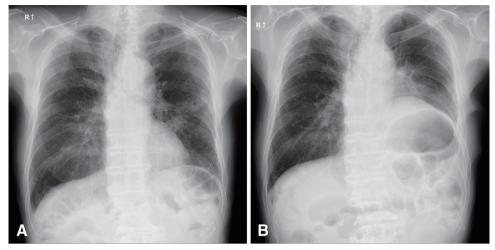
The chest X-rays were taken before and 22 days after the surgery. (A) There were no indications of pericardial defects before the surgery. (B) After the surgery, leftward displacement of the heart and left diaphragmatic elevation, suspected of phrenic-nerve paralysis, were observed.
